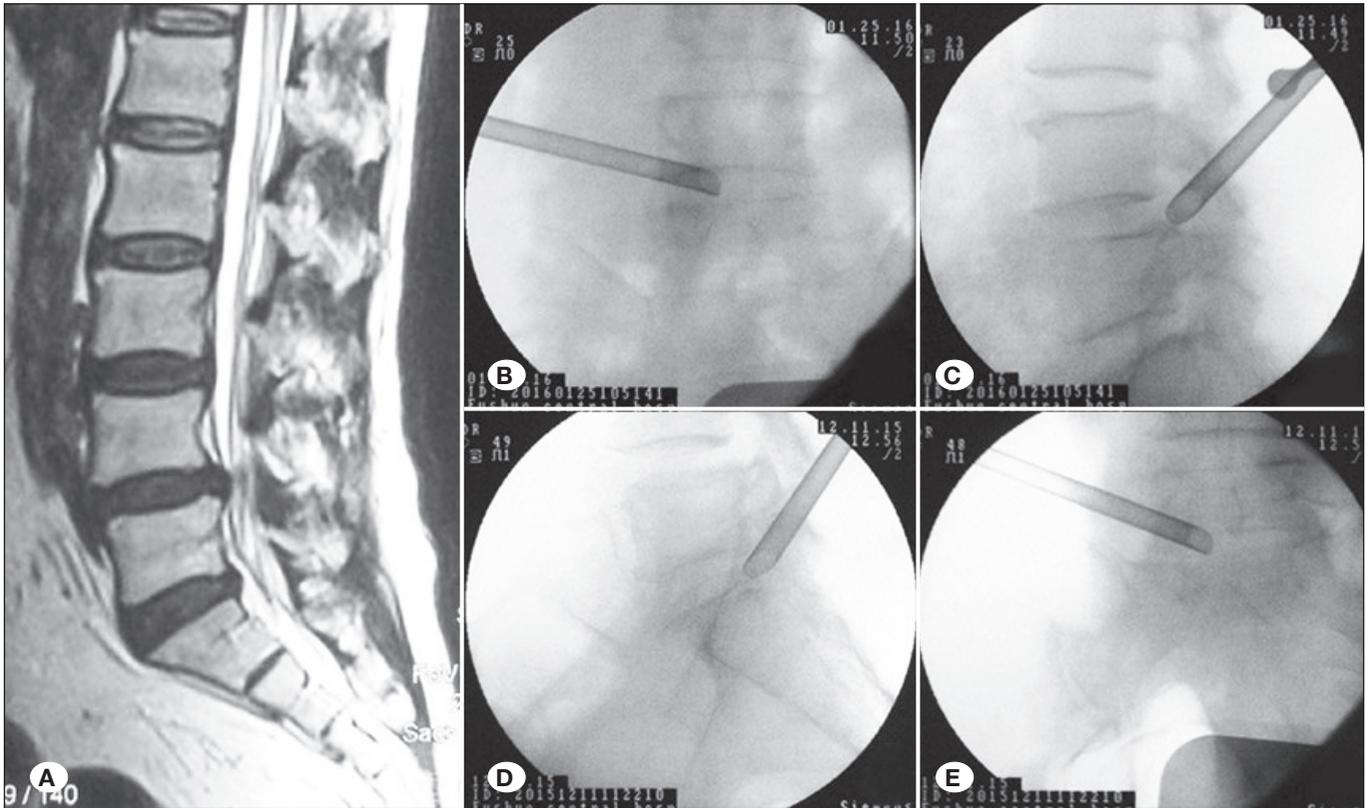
Imaging results for a male patient (65 years old) diagnosed with degenerative herniation with secondary spinal stenosis with intermittent claudication (200 m). Modified SSNB test revealed positive results for both segments. The patient was treated with PETLS for both L4–L5 and L5–S1 segments. A) Preoperative MRI displaying L4–L5 and L5–S1 herniation. B) and C) Location of working cannula of L4–L5 segment under X-ray during PETLS. D) and E) Location of working cannula of L5–S1 segment under X-ray during PETLS.
